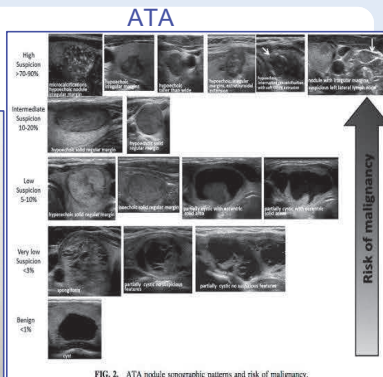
ATA nodular sonographic patterns and risk of malignancy.
